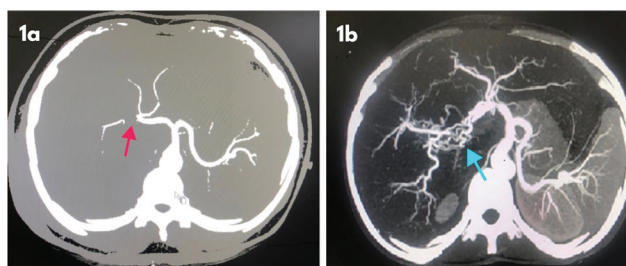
Computed tomography angiographic image showing (1a) showing right hepatic artery injury (red arrow), (1b) showing formation of web of collaterals after right hepatic artery injury (blue arrow).
